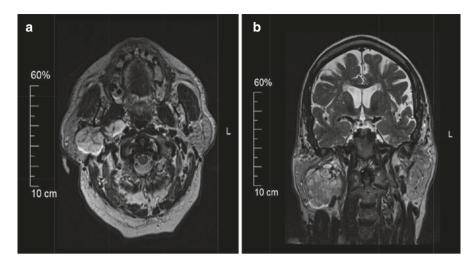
Axial (a) and coronal (b) MRI showing a large mucoepidermoid cancer of the parapharyngeal space on the right side
